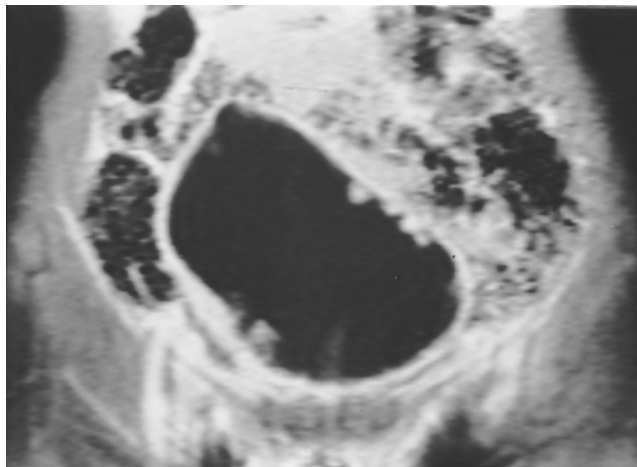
Multiple papillary tumors. Coronal T1-weighted gadolinium-enhanced fat-suppressed spin-echo image. The enhancing papillomas are well shown as enhancing mass lesions in a background of low signal intensity of non-gadolinium-containing urine.
